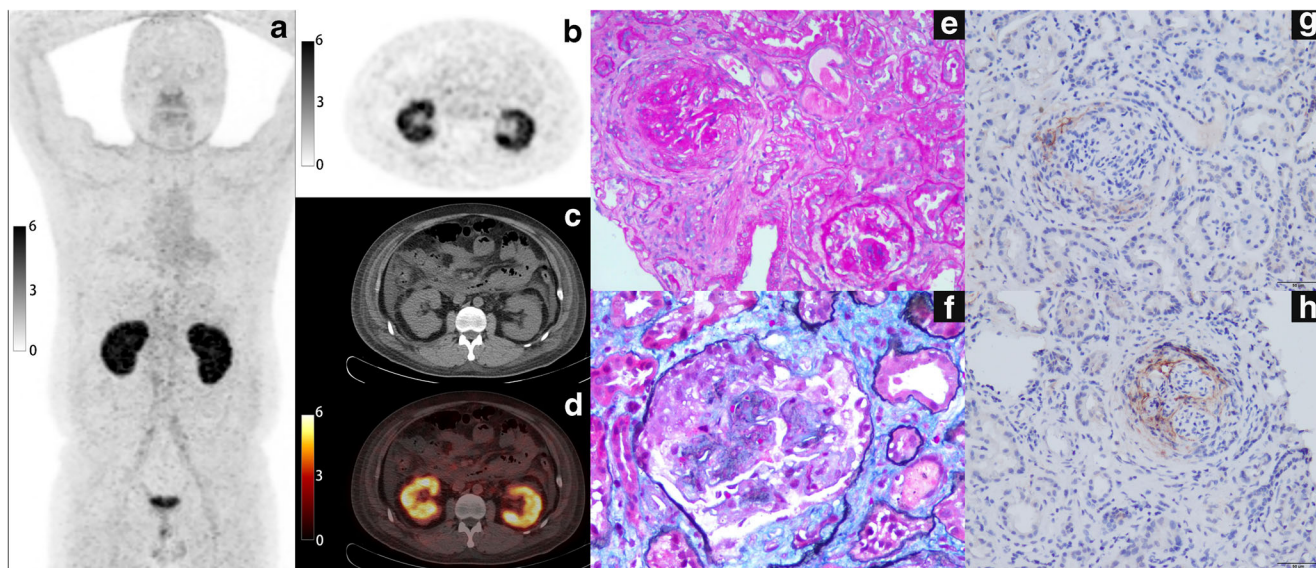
A 30-year-old man presented with edema of his lower limbs and face for more than 4 months, with foamy urine and pleural effusion. The maximum intensity projection (MIP) image of whole-body [^{68}Ga]Ga-FAPI-04 PET (a) shows diffuse uptake of radiotracer in both kidneys. The cross-sectional images (b–d) show heavy radiotracer uptake in both kidney parenchyma, and the SUVmax was 7.3, suggesting diffuse
